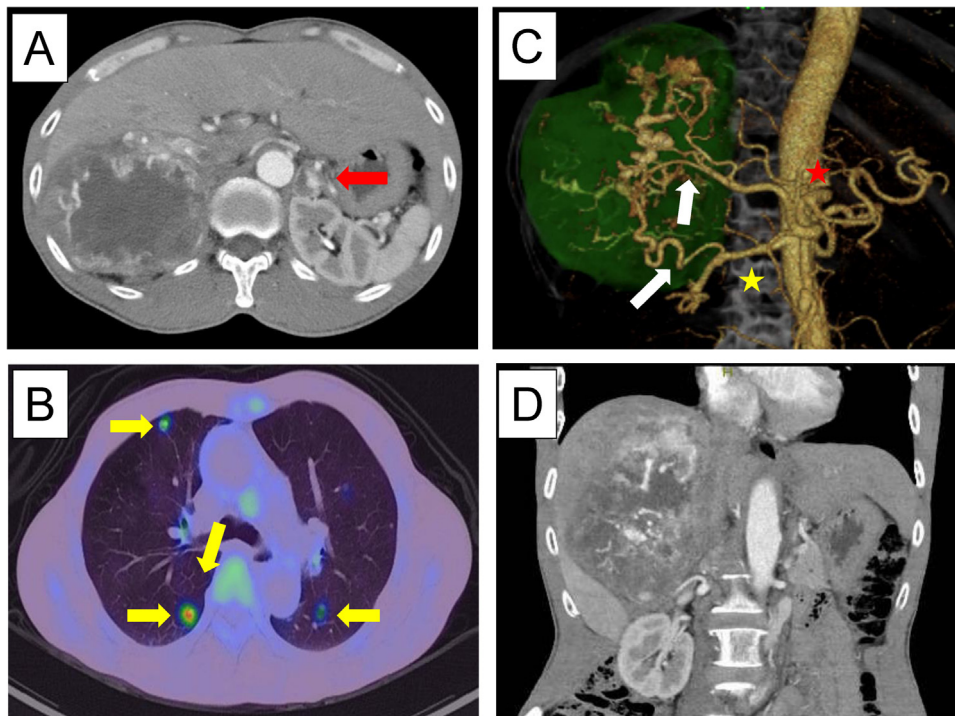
A. Axial contrast-enhanced computed tomography (CT) image showing a 14-cm diameter right adrenal tumor and left adrenal metastasis (red arrow). B. Coronal CT showing feeding arteries arising from the renal artery (yellow arrows). C. Three-dimensional CT showing many feeding arteries (white arrows) branching from the celiac trunk (red star) and renal artery (yellow star). D. 18F-fluoro-2-deoxyglucose positron emission tomography/computed tomography showing abnormal uptake in lung metastases (yellow arrows).
